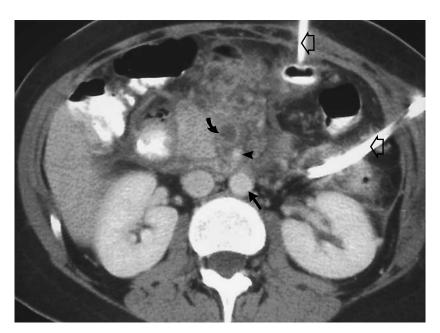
Computed Tomographic Scan of the Abdomen in a Patient with Acute Thrombosis of the Superior Mesenteric Vein Complicating Acute Pancreatitis.
